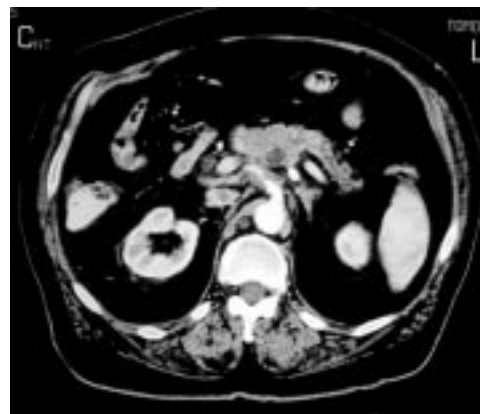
High resolution abdominal computed tomogram.
